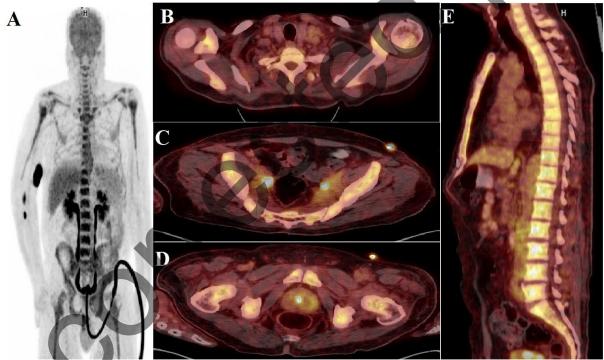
18F-FDG PET/CT imaging showed increased FDG uptake in the left supraclavicular area (B) and bilateral paraaortic-para iliac lymph nodes in the abdomen (C). Additionally, diffusely increased FDG uptake was observed in the prostate gland parenchyma (D) and bone marrow (A and E)
